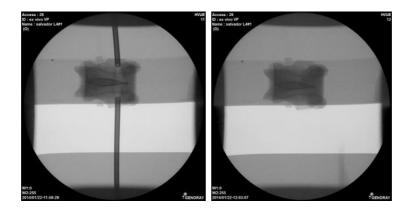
8: Analysis by X-ray.Left; the fracture without the paste. Right; the fracture filled with the paste
